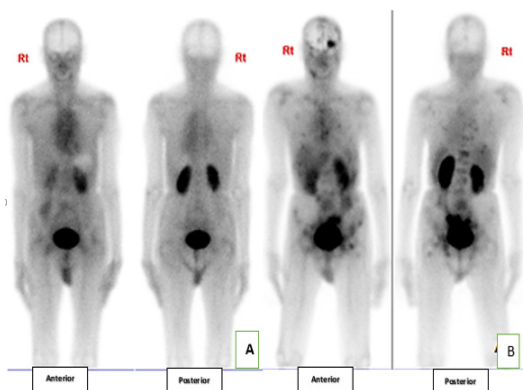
Last Post-therapy <sup>177</sup>Lu-PSMA scan showing no receptor avid disease just bone marrow activity and 1st Post-therapy <sup>177</sup>Lu-PSMA scan showing receptor avid disease involving the bony skeleton.
